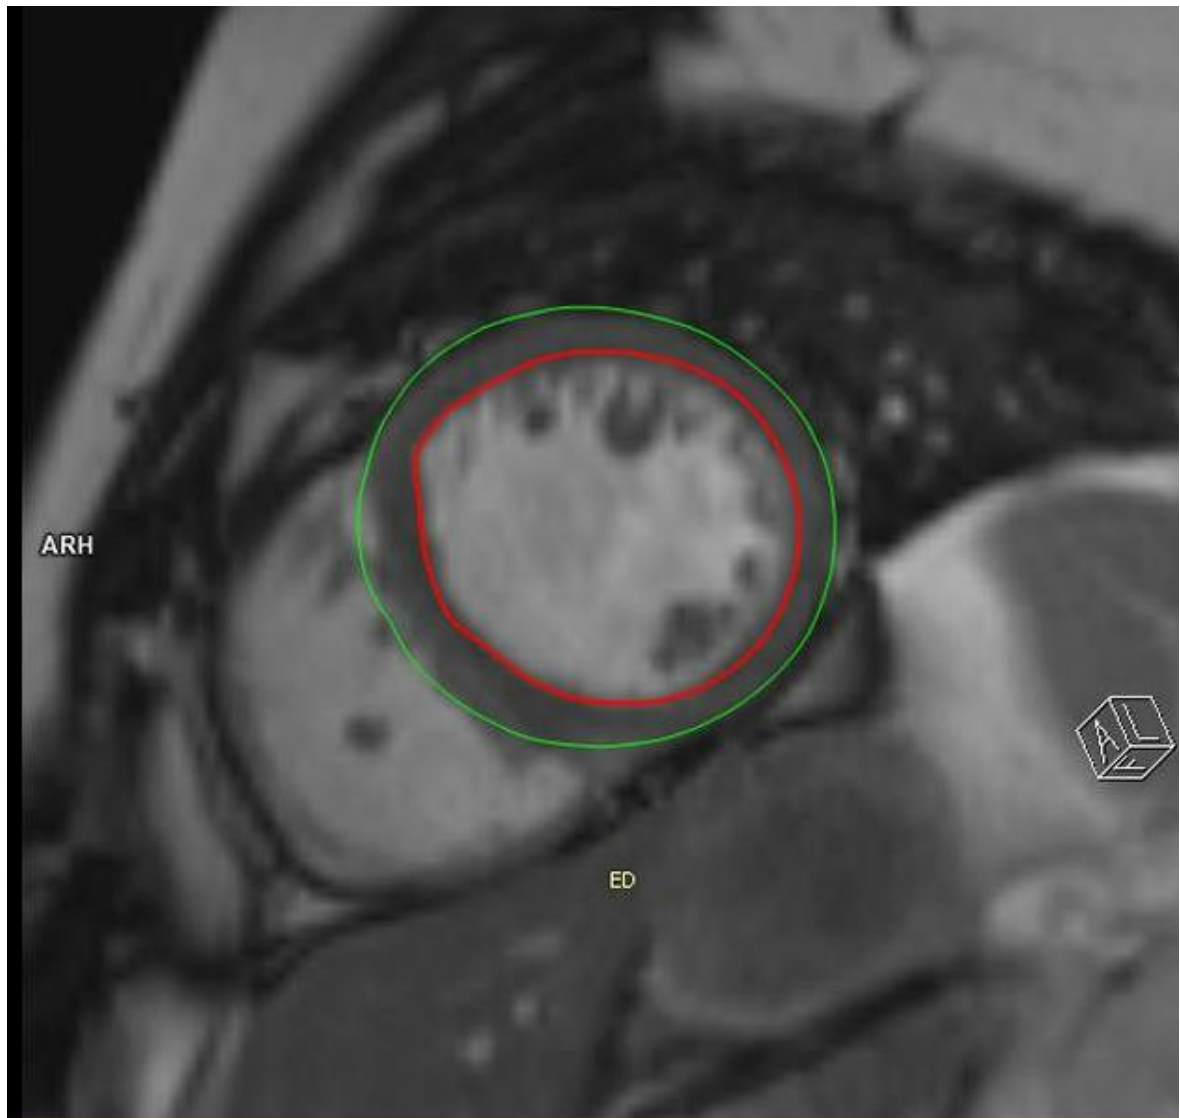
LV dimensions and function assessment with Cardiac MRI. Short axis images of the left ventricle are taken in end-systole and end diastole. The endocardial border is mapped (red border) and the epicardial border is mapped (green border).
